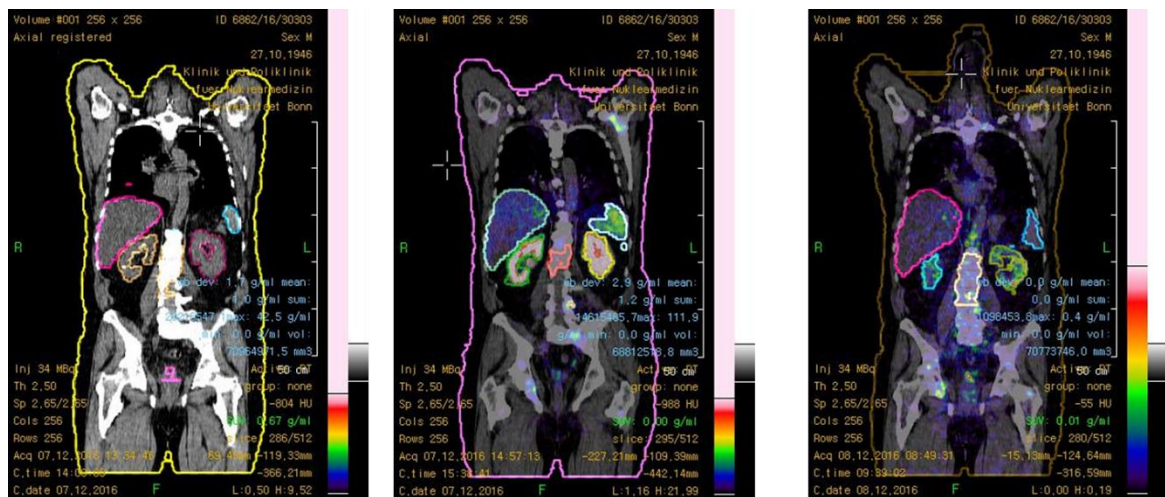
VOI drawn in (a) CT image at 45 min, (b) PET/CT images at 2 h and (c) at 18h. OLINDA/EXM software (Hermes, Germany) was used to calculate mean organ absorbed doses and effective doses (ICRP103 factors) by adjusting for patient's body weight. It was done by multiplying the reference adult male body weight with fraction determined from dividing the patient weight with reference adult weight. The mean of residence
